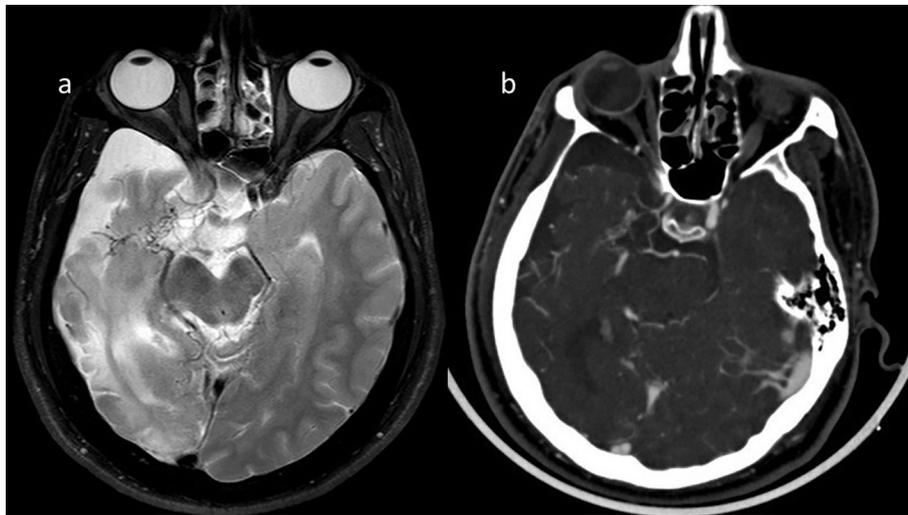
A 26-year-old male patient, vascular collateral structures (a) and parenchymal volume loss are present at the right MCA level on MRI (T2 weighted). CT angiography (b) indicates decreased right ICA calibration and vascular collateral structures at the MCA level. The findings are consistent with Moyamoya disease.
